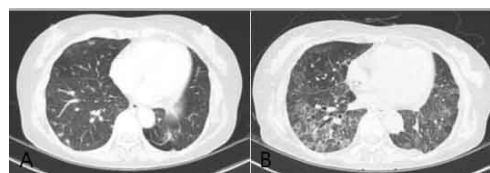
A. Initial Chest CT. R/O progression of metastatic nodules. B. CT after taking fluconazole: Decreased in numbers and size of multiple irregular shaped nodules in B lungs but poor visualization of most of the nodules d/t thick section.
